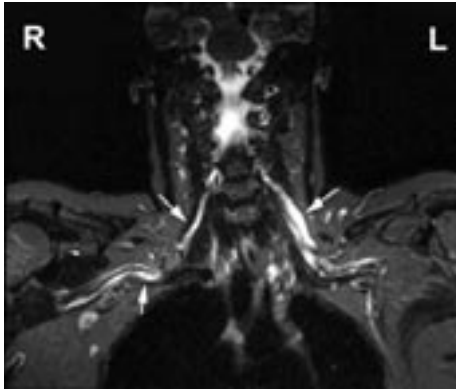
Coronal, fat-suppressed, T2-weighted, fast-spin echo MRI of the brachial plexus of a patient with multifocal motor neuropathy. Arrows indicate swelling and increased signal intensity. The abnormalities are more pronounced on the -clinically most affected- left than on the right side.
